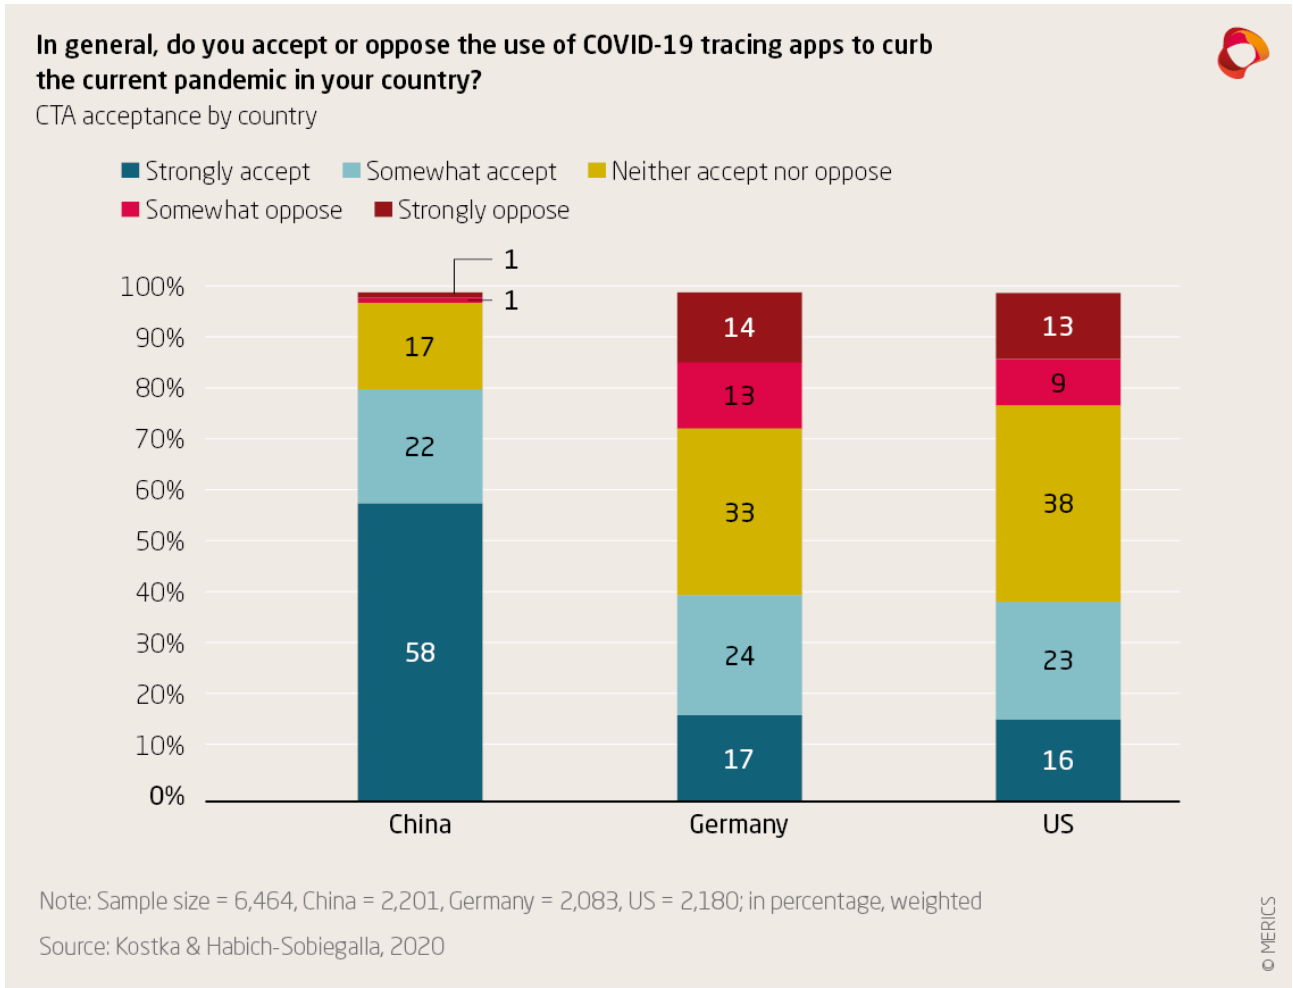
CTA acceptance by citizens in China, Germany and the US.
